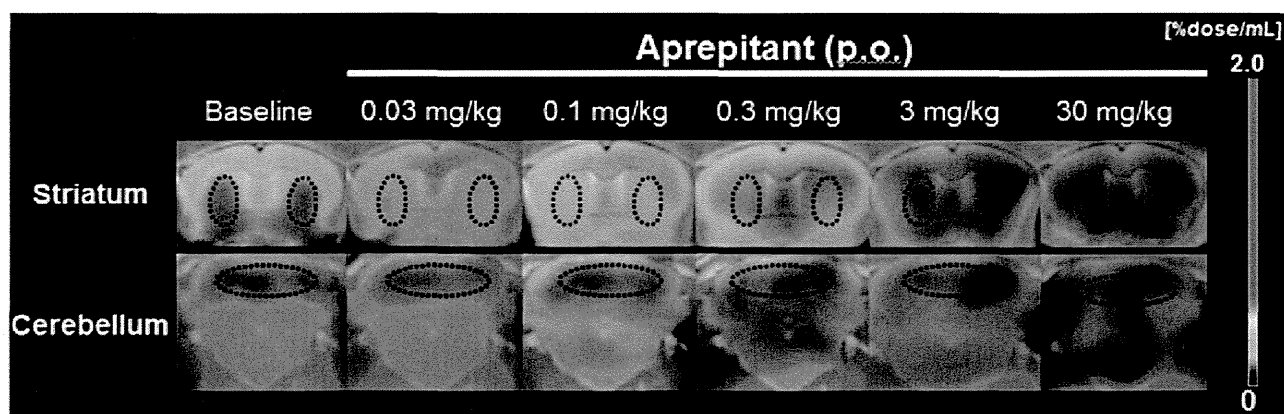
Representative coronal PET images showing [^{18}F]FE-SPA-RQ distribution in gerbil brains at baseline and after oral administration (per os; p.o.) of aprepitant. PET data were generated by summation of dynamic data at 0–6 h after intravenous radioligand injection, and were merged onto the MRI template. ROIs (outlined by dots) were placed on the striatum (upper row) and cerebellum (lower row).
